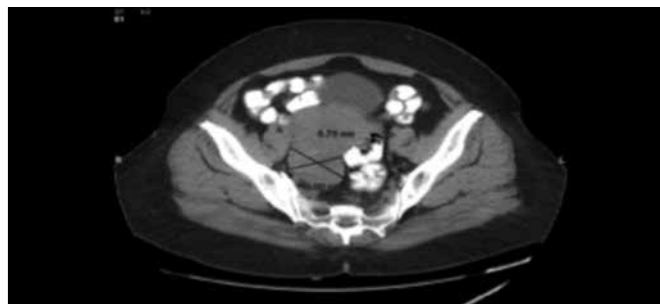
53x42 mm measured right adnexal mass in CT scan
